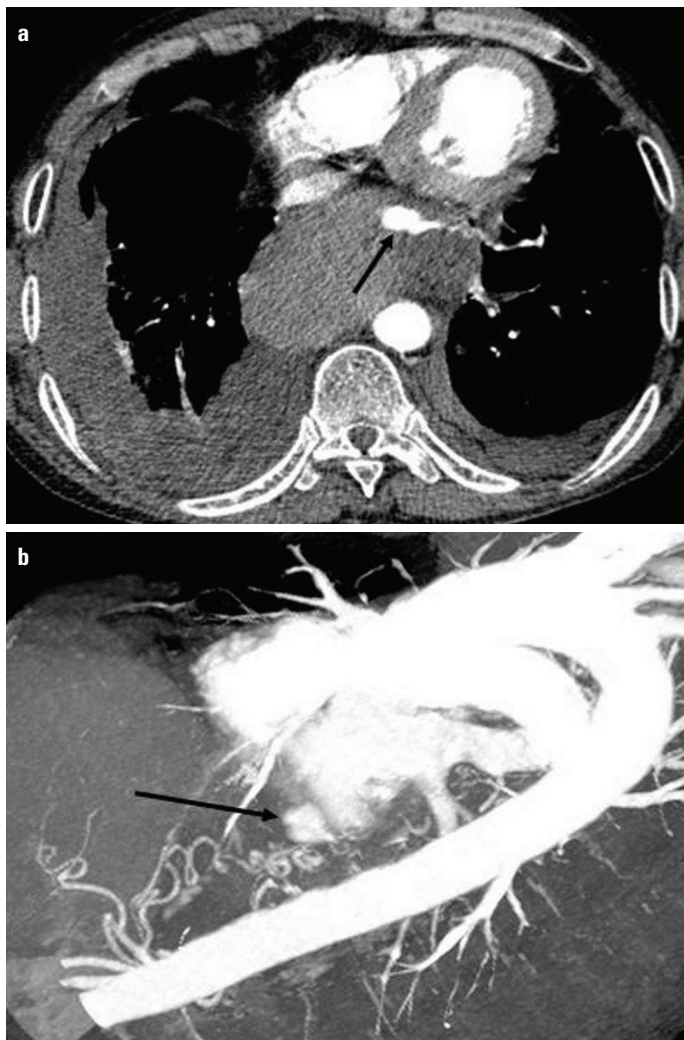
(a) Contrast-enhanced CT image demonstrating cystic arterial aneurysm within mediastinal hematoma, together with bilateral pleural effusion. (b) Oblique reconstruction image showing the branch of the left gastric artery feeding aneurysm
